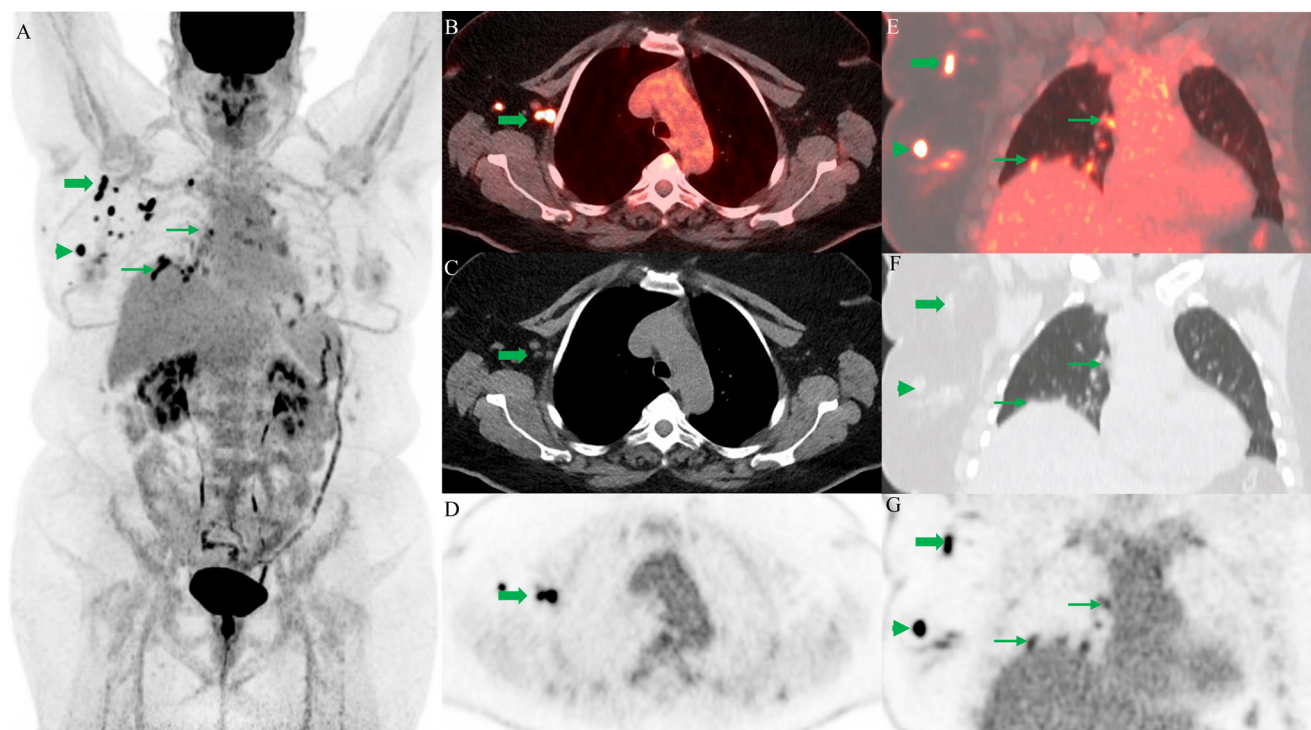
Selected images from the FDG PET/CT in this patient with recently diagnosed right breast cancer. Coronal FDG PET maximum intensity projection (MIP; A) demonstrates multifocal hypermetabolic right breast lesions (arrowhead) with several additional hypermetabolic right axillary lymph node deposits (thick arrow) and pulmonary nodules in both lungs (thin arrows). Transaxial fused FDG PET/CT (B) CT (C) and PET (D) show several hypermetabolic right axillary lymph nodes (thick arrows) with proven metastatic involvement. Coronal fused FDG PET/CT (E) CT (F) and PET (G) show the primary hypermetabolic breast carcinoma (arrowheads), right axillary nodal disease (thick arrows) and ground glass and partially solid pulmonary nodules in the right lung (thin arrows).
